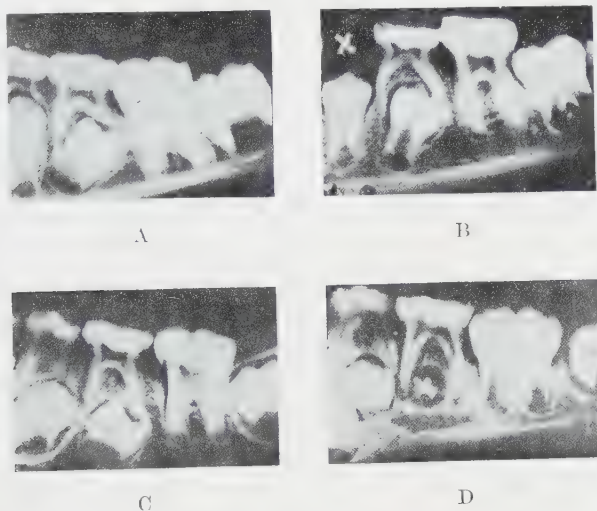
Dental radiographs of 4 Bushman children originally published by Drennan as examples of his claim that the second molars are advanced over the premolars, "showing the same order of eruption as in the apes, and the direct inverse of that in the European" (Drennan, '32 pp. 494). However  $P_2$  is congenitally missing in D, both  $P_2$  and  $M_2$  are unerupted in C, and the order of cutting the gum would most likely be  $P_2M_2$  for the remaining two children, A and B. See text for further details.
